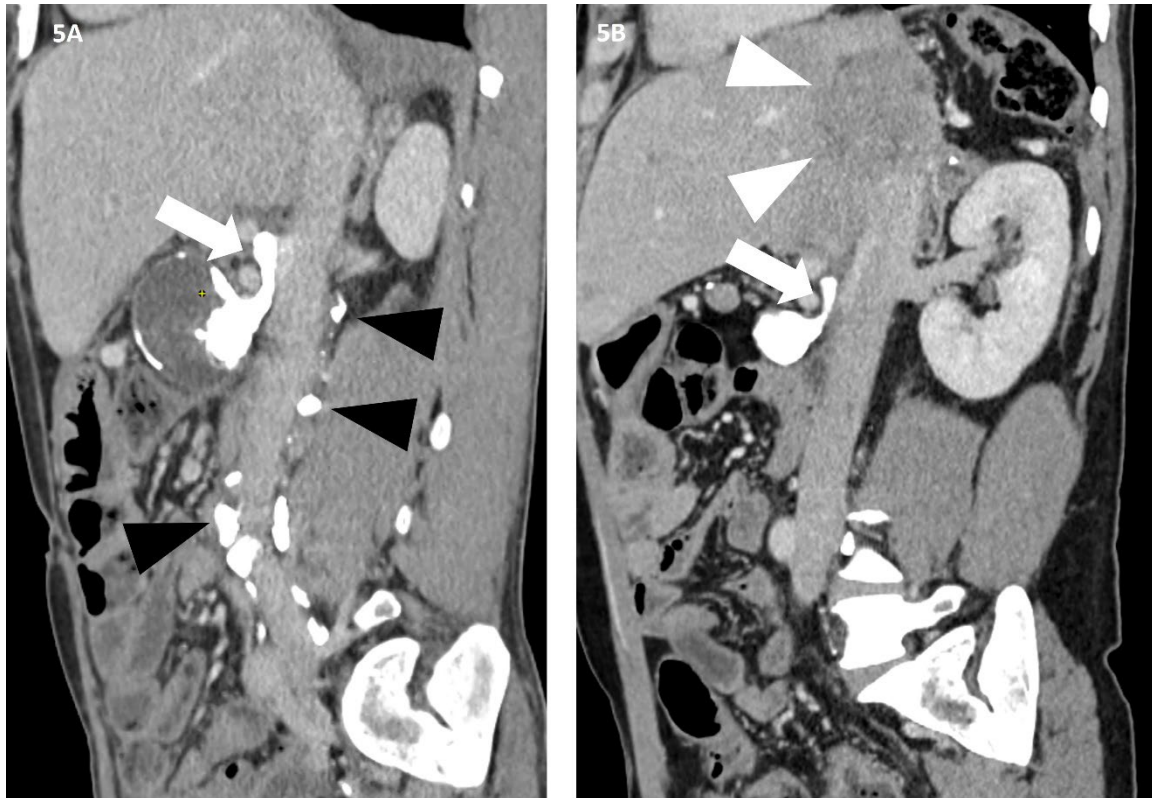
Follow-up CT scan after 1 month (A) and 1 year (B) showing absence of ascites and remnants of glue (white arrows) as well as partial (A) and complete (B) resolution of the lymphocele. Note the retroperitoneal lymph nodes filled with Lipiodol after lymphangiography (black arrowheads, A) and the hepatic tumor recurrence after 1 year (white arrowheads, B).
